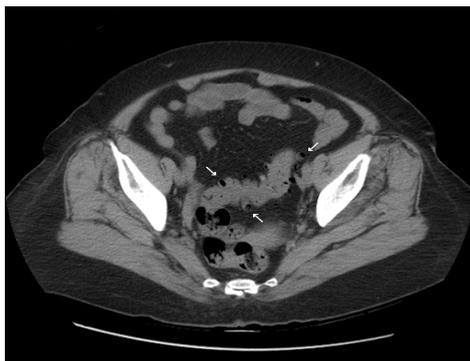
This figure shows several sigmoid diverticula (arrows). (CT scan image).
